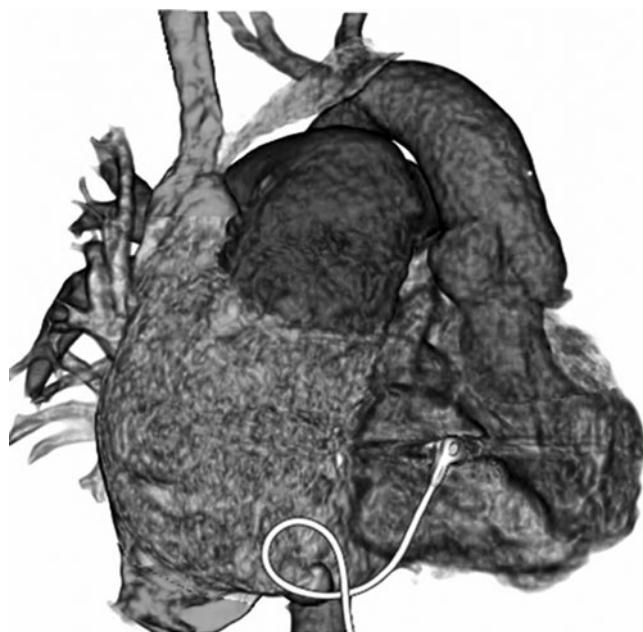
Preoperative three-dimensional computed tomography
